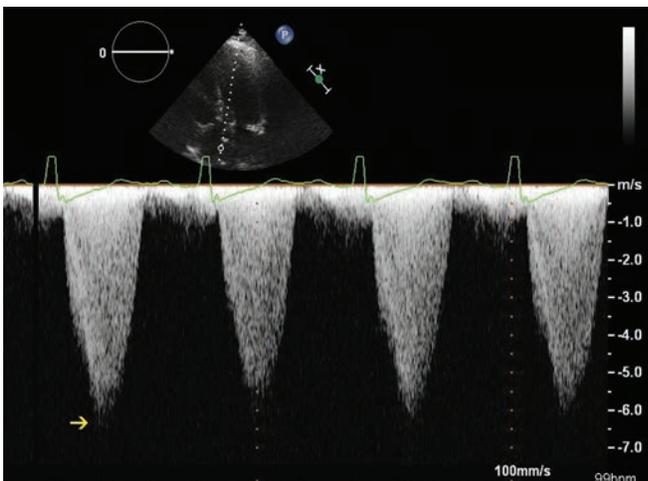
Two dimensional transthoracic apical five chamber view with continuous wave Doppler flow across aortic valve.
